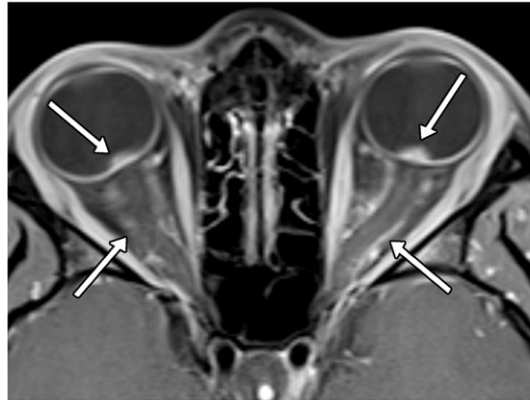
Overlapping of MOG antibody–associated disease and anti-*N*-methyl-D-aspartate receptor (NMDAR) encephalitis in a 15-year-old girl with headache, seizures, speech dysfunction, right arm palsy, and encephalopathy. Clinical relapse occurred 4 weeks later with headache, blurry vision, and diplopia. Three years later, she experienced headache, nausea, hypoventilation and gradually encephalopathy, elevation of lumbar puncture cerebrospinal fluid opening pressure, and seizures. (a, b) Axial apparent diffusion coefficient (ADC) map (a) and postcontrast T1-weighted image (b) at onset show restricted diffusion (arrow in a) and leptomeningeal enhancement (arrowheads in b) in the left parietal region. (c) Axial postcontrast T1-weighted image 4 weeks later shows enhancement of the optic nerve head and perineural optic nerve enhancement and swelling (arrows). (d) Axial ADC map 3 years later shows restricted diffusion in the right parahippocampal gyrus, hippocampus (arrows), and thalamus (not shown).
